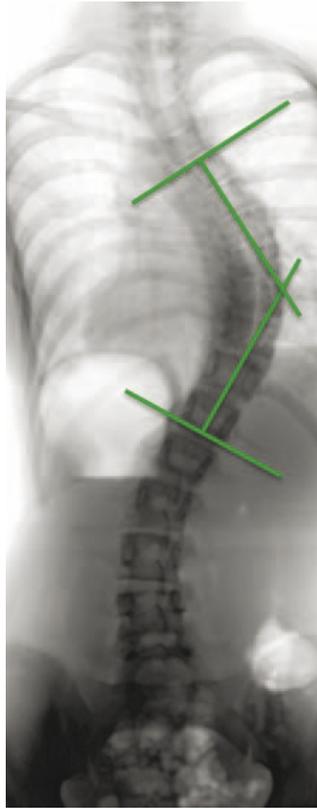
Cobb angle measurement of the coronal plane deformity on an anterior-posterior radiograph of a 14-year old girl with adolescent idiopathic scoliosis.
